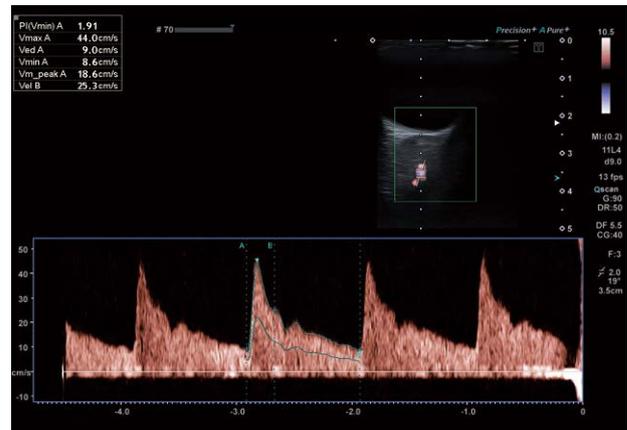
Maternal ophthalmic artery Doppler.
